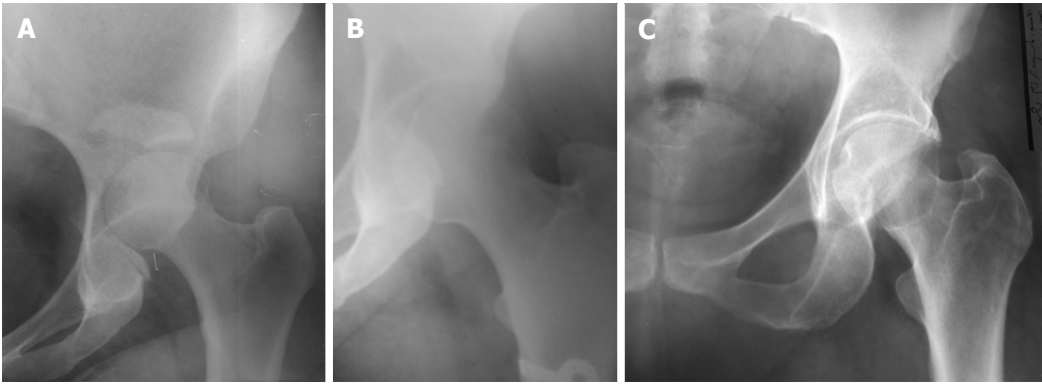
Plain radiographs of right hip joint for a 42-year-old female, was diagnosed two days after a motor car accident. A: A posterior dislocation of the right hip with acetabular fractures; B: A radiograph was taken two weeks after closed reduction shows stable reduction; C: A radiograph was taken seven years after reduction shows no signs of avascular necrosis in the head of right femur.
